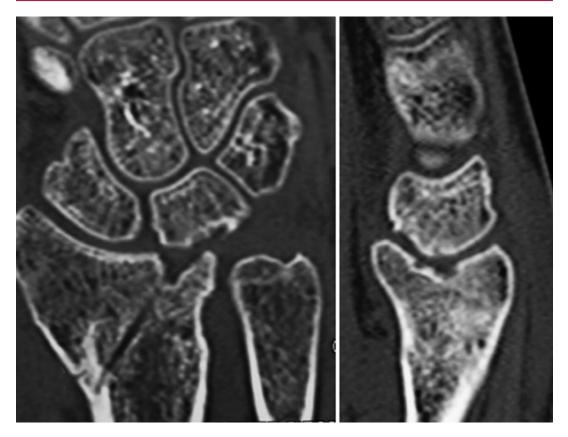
Preoperative CT scan of a patient with severe damage on the lunate articular surface by the bony spur on the radius (© Piñal in del Piñal et al. 2012)
